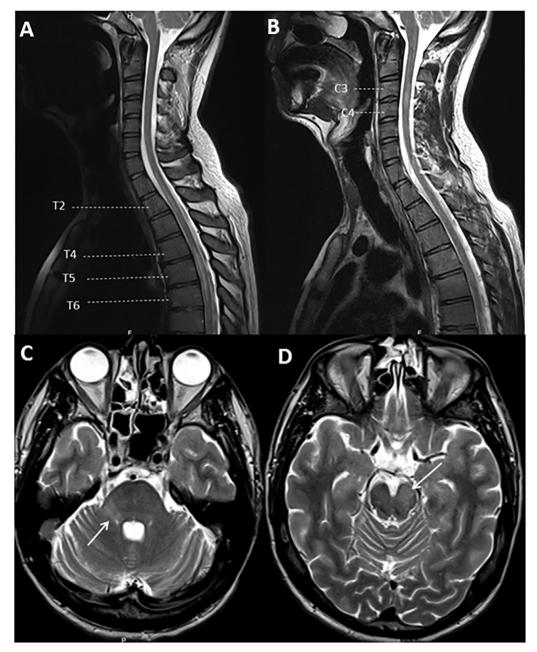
Spinal cord and brain MRI First spinal cord MRI assessment showed a T2 hyperintensity extending from T4 to T6 and a second T2 hyperintensity at the T2 level (A, T2-weighted images). MRI 3 months later revealed a new T2 hyperintensity at the C3-C4 level (B, T2-weighted images). Axial T2-weighted images showing 2 hyperintense brainstem lesions (arrows) involving the right cerebellar peduncle (C) and the left cerebral peduncle (D).
